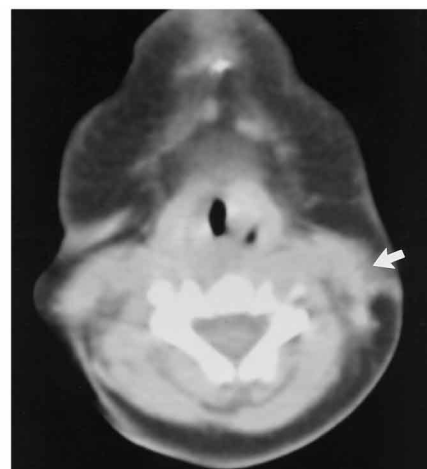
Axial CT scan shows diffuse infiltration of the subcutaneous fatty tissues of the left side of the cheek and multiple poorly defined posterior subcutaneous nodules (arrows).
